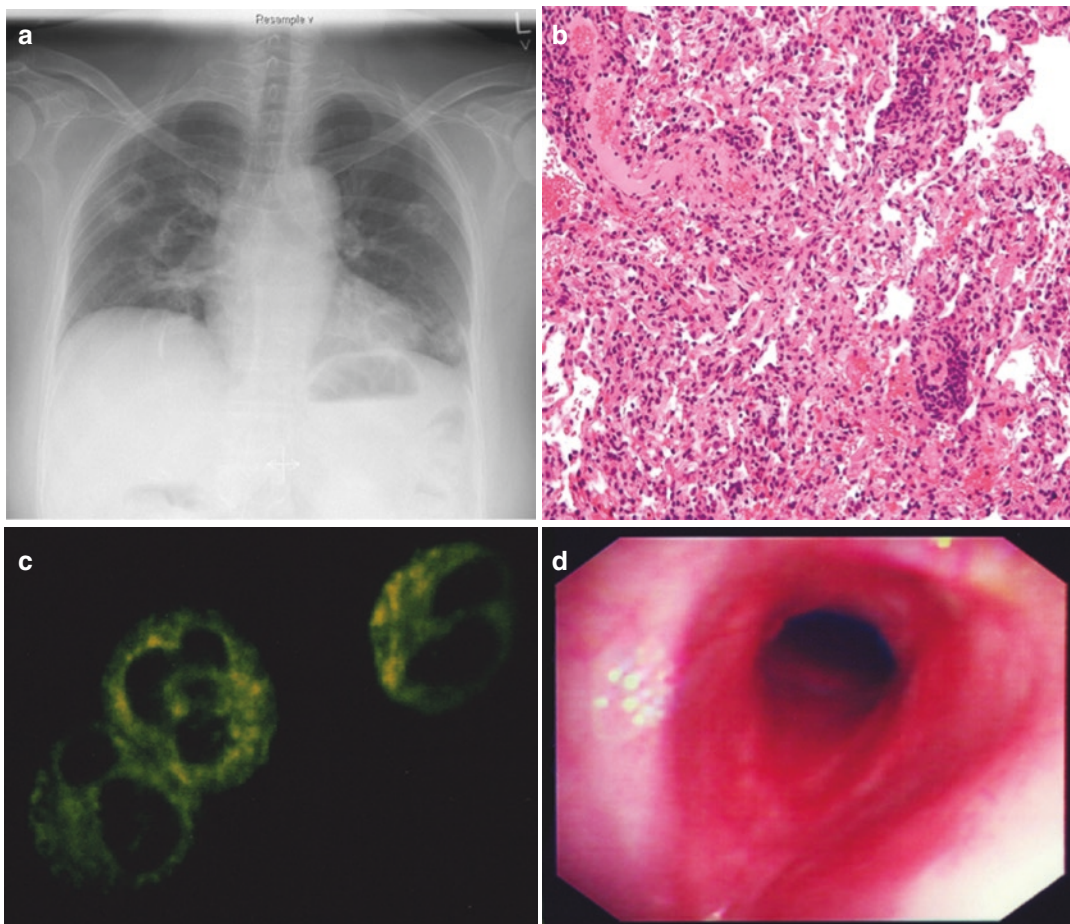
(a–d) Granulomatosis with polyangiitis. (a) A chest radiograph in a patient with multiple lung nodules with both cavitory and solid appearance. (b) CT guided biopsy undertaken due to concern of metastatic carcinoma shows small and medium vessel vasculitis with necrosis
